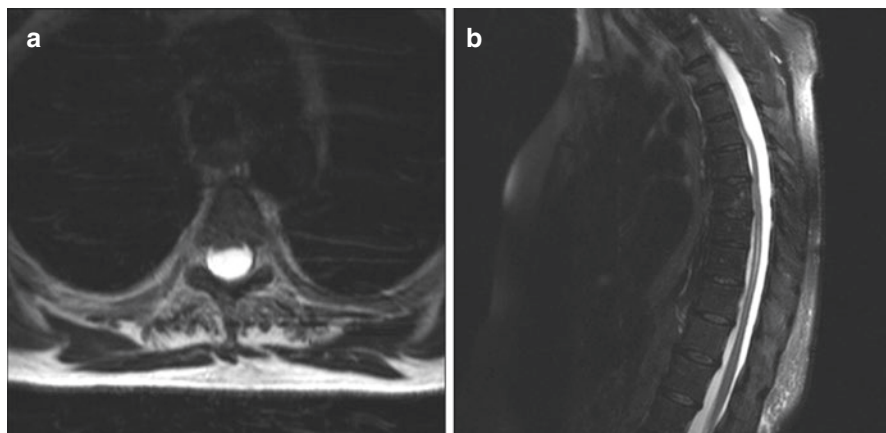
T2-weighted axial and sagittal MRI showing large cystic lesion compressing the spinal cord at its posterior aspect. Please note the content of the cyst is equal to CSF
